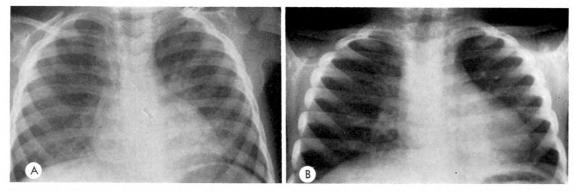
Case II. (A) April 23, 1962: Chest roentgenogram taken I hour after ingestion of furniture polish showing mild mottled densities adjacent to both lower heart borders. (B) June 15, 1962: Frontal roentgenogram showing clearing of pneumonitis after nearly 8 weeks.
